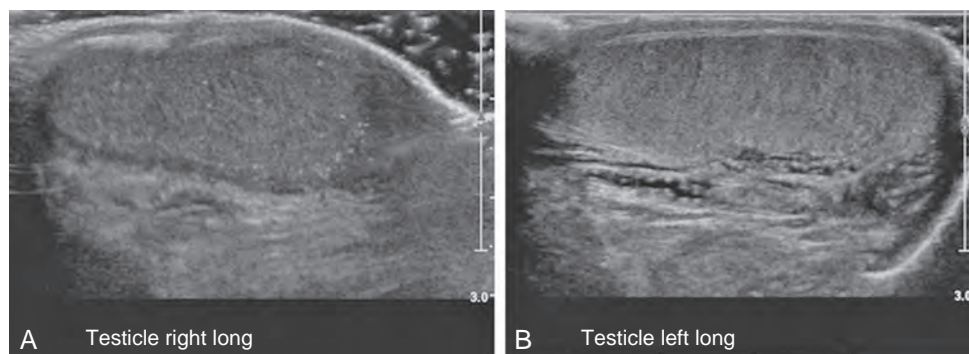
Associated sonographic abnormalities in boys with cryptorchidism. Ultrasound images from an 11-year-old boy with testicular asymmetry who underwent bilateral orchidopexies in infancy. A, Right microlithiasis. B, Ectasia of the left rete testis.
